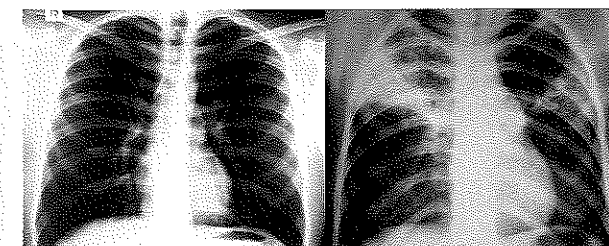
A normal lung X-ray on the left, and an X-ray of a lung with TB on the right.
